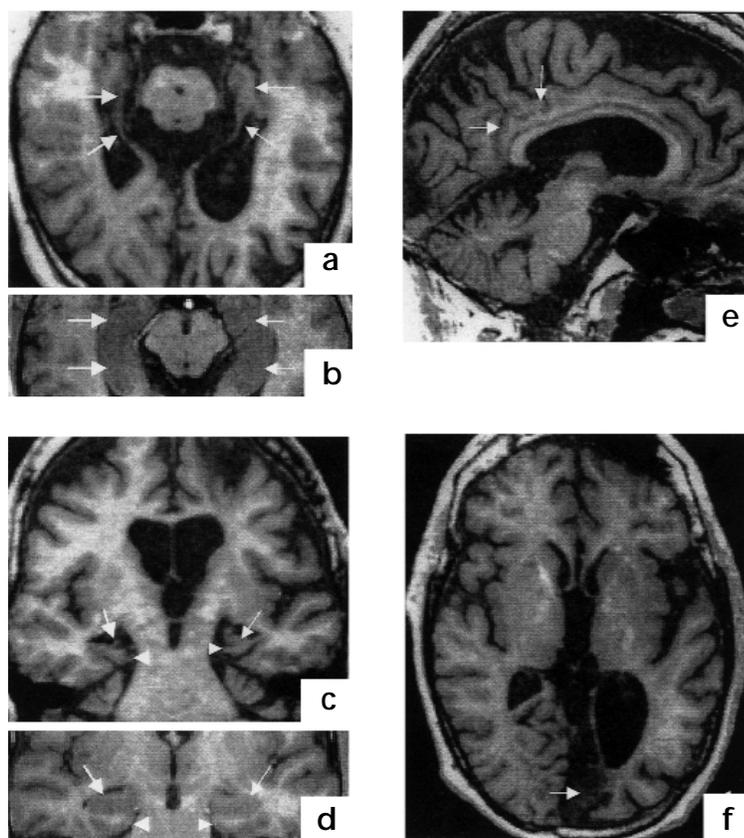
Magnetic resonance imaging slices showing K.C.'s pathology. (a) Axial view showing severely atrophic right and left hippocampus (arrows). (b) Axial view showing controls' intact right and left hippocampus (arrows). (c) Coronal view showing severe atrophy of the right and left hippocampus (arrows) and atrophy of the right and left parahippocampal gyri (arrowheads). (d) Coronal view showing controls' intact right and left hippocampus (arrows) and right and left parahippocampal gyri (arrowheads). (e) Midsagittal view showing relatively preserved posterior cingulate (arrows). (f) Axial view showing left medial occipital infarction (arrow).
